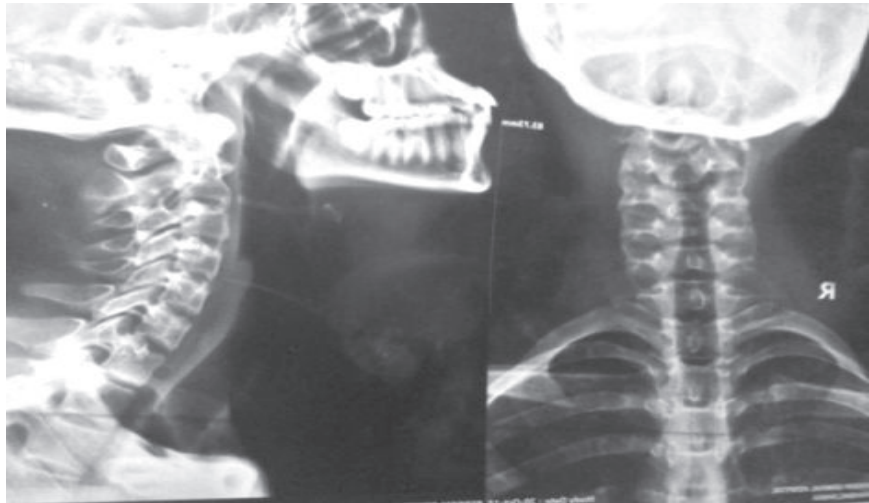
X-ray of Cervical Spine at Final Follow-up to measure the residual head tilt traction*
